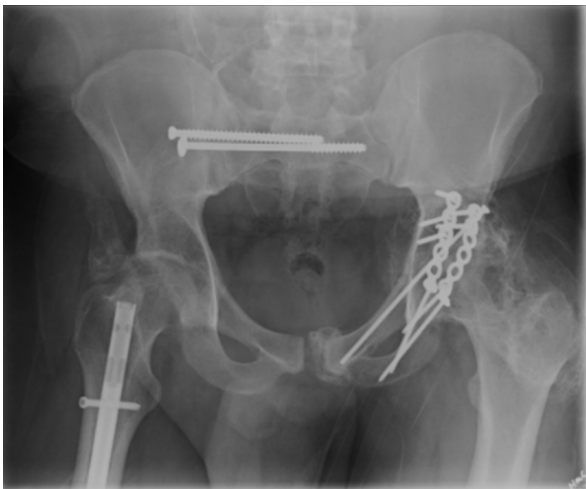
26-year-old man with polytrauma who developed mesenteric ossification. AP pelvis radiograph 10 months after initial trauma showing bony densities at the insertion site of the right femoral IM rod, overlying the left hip, overlying the symphysis pubis, and overlying the lower abdomen.
